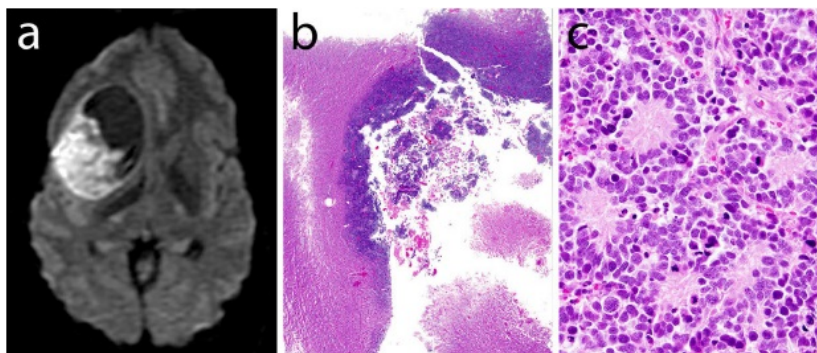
Glioblastoma with primitive neuronal components (GBM-PNC). (a) In this Diffusion-weighted magnetic resonance image (DW-MRI) the restricted diffusion shows the more cellular primitive component. (b) The primitive clone in this GBM-PNC is evident as a highly cellular nodule within an otherwise classic diffuse astrocytoma. (c) Well-formed Homer Wright rosettes, nodules containing primitive cells that display neuronal differentiation, were seen in the primitive portion of this GBM-PNC. Image courtesy of [Louis et al., 2016].
